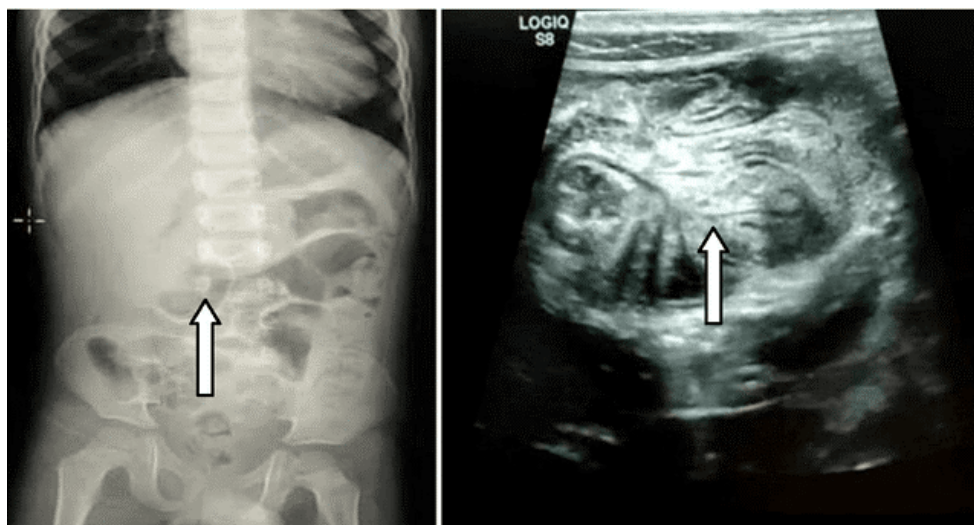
A. X-ray abdomen of intussusception of the pediatric patient. B. USG showing target sign
